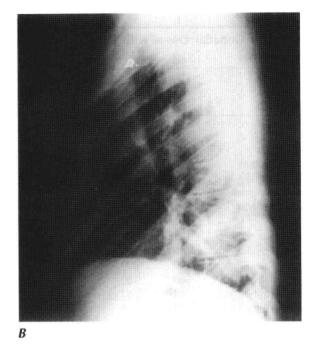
Without a well-defined border, an anatomical structure can be invisible. *A*. A pleural-based mass is easily seen on the PA radiograph because it has a distinct border with the adjacent air-filled lung (*arrow*). *B*. On the lateral radiograph, the pleural-based mass is invisible because its margins are indistinct. *C*. A CT scan clearly demonstrates the nature of the lesion. The pleural-based mass tapers gradually as it intersects with the chest wall. In addition, there is a contiguous mass on the outer surface of the chest wall (*arrow*). The lesion proved to be extrapulmonary tuberculosis. (Copyright David Schwartz, MD)
